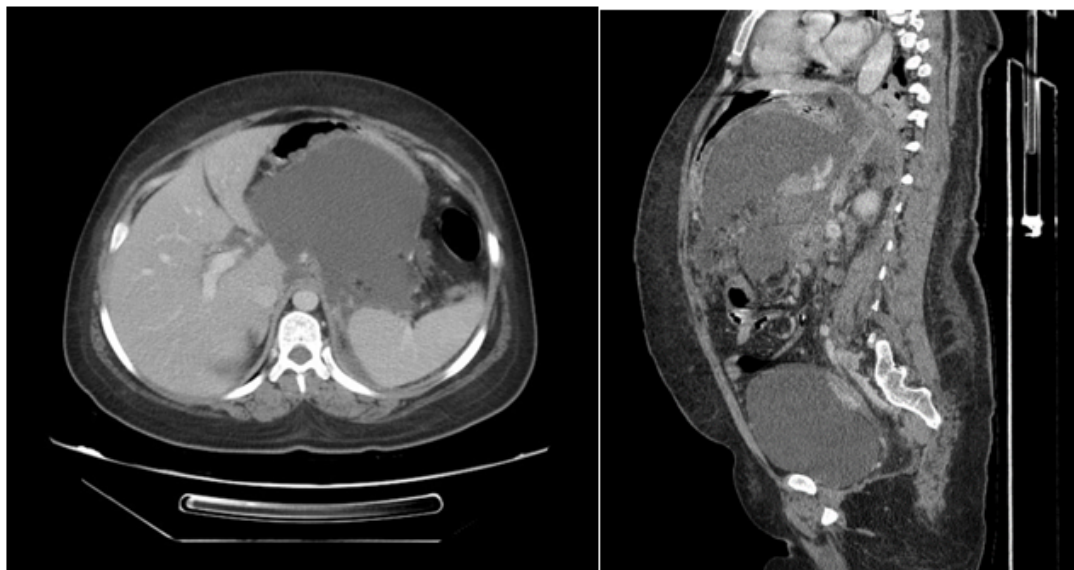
CT sections: gastric bulging of pseudocysts of the pancreas.
